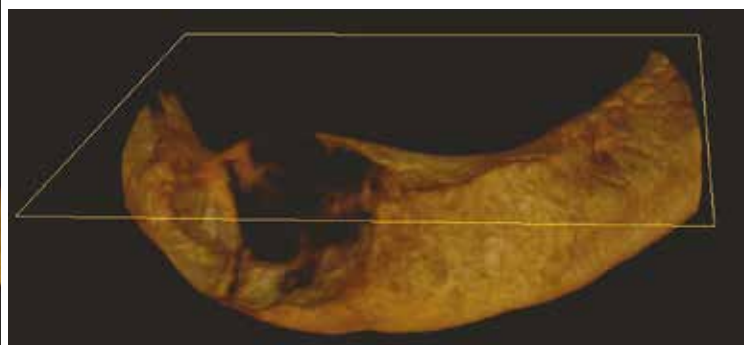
Evaluation of lesion size on cone beam tomography.
